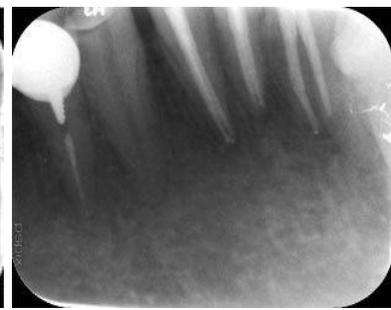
Six-month follow-up radiograph
